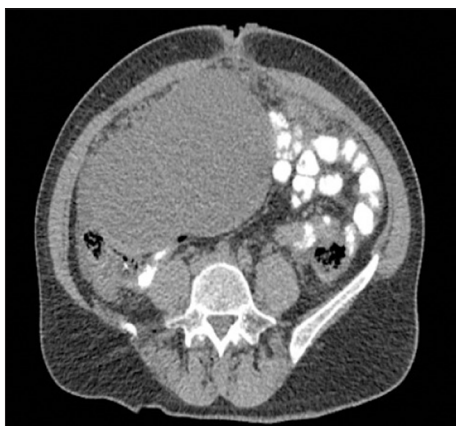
Contrast-enhanced magnetic resonance imaging of the abdominal cavity and pelvis showed an expansive tumorous formation covering the uterus with carcinomatosis of the peritoneum (transversal view).
